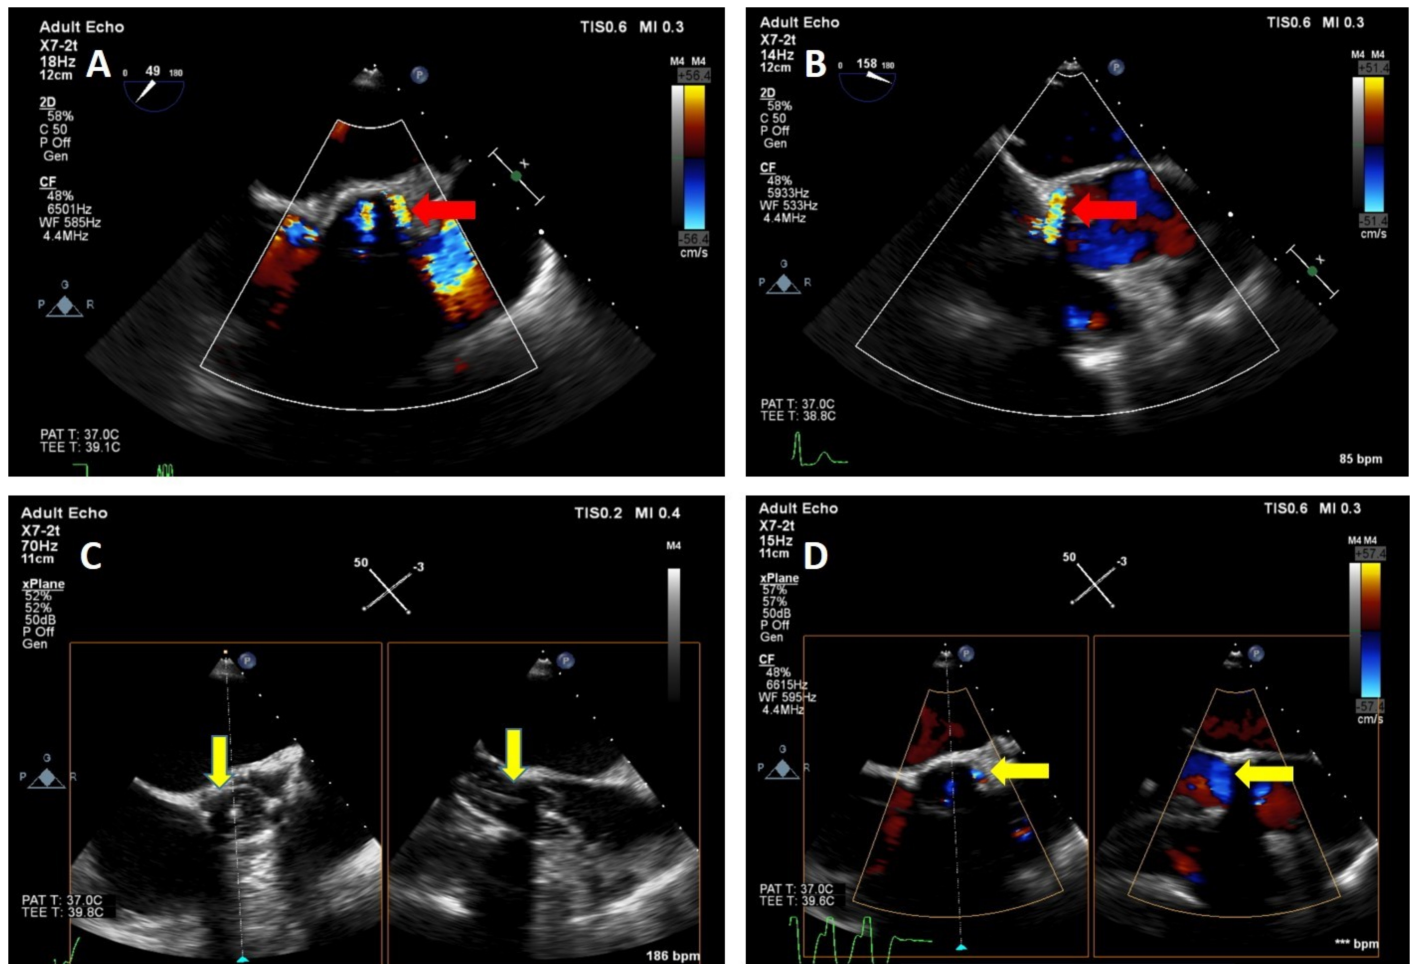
Patient 2. (A, B) Transesophageal echocardiographic short-axis and color-Doppler images revealing a severe paravalvular defect with substantial regurgitation adjacent to the 19-mm Edwards Intuity prosthesis.
